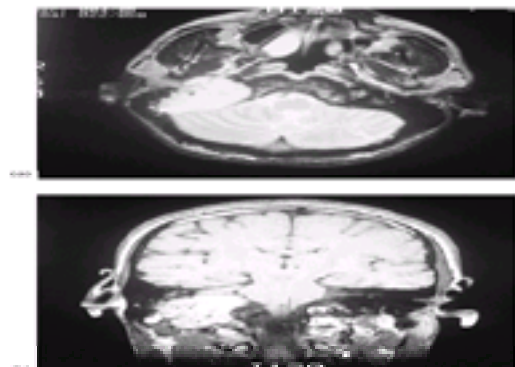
Glomus jugulare tumour (left of photograph) on (a) axial MRI scan; (b) coronal MRI scan.
